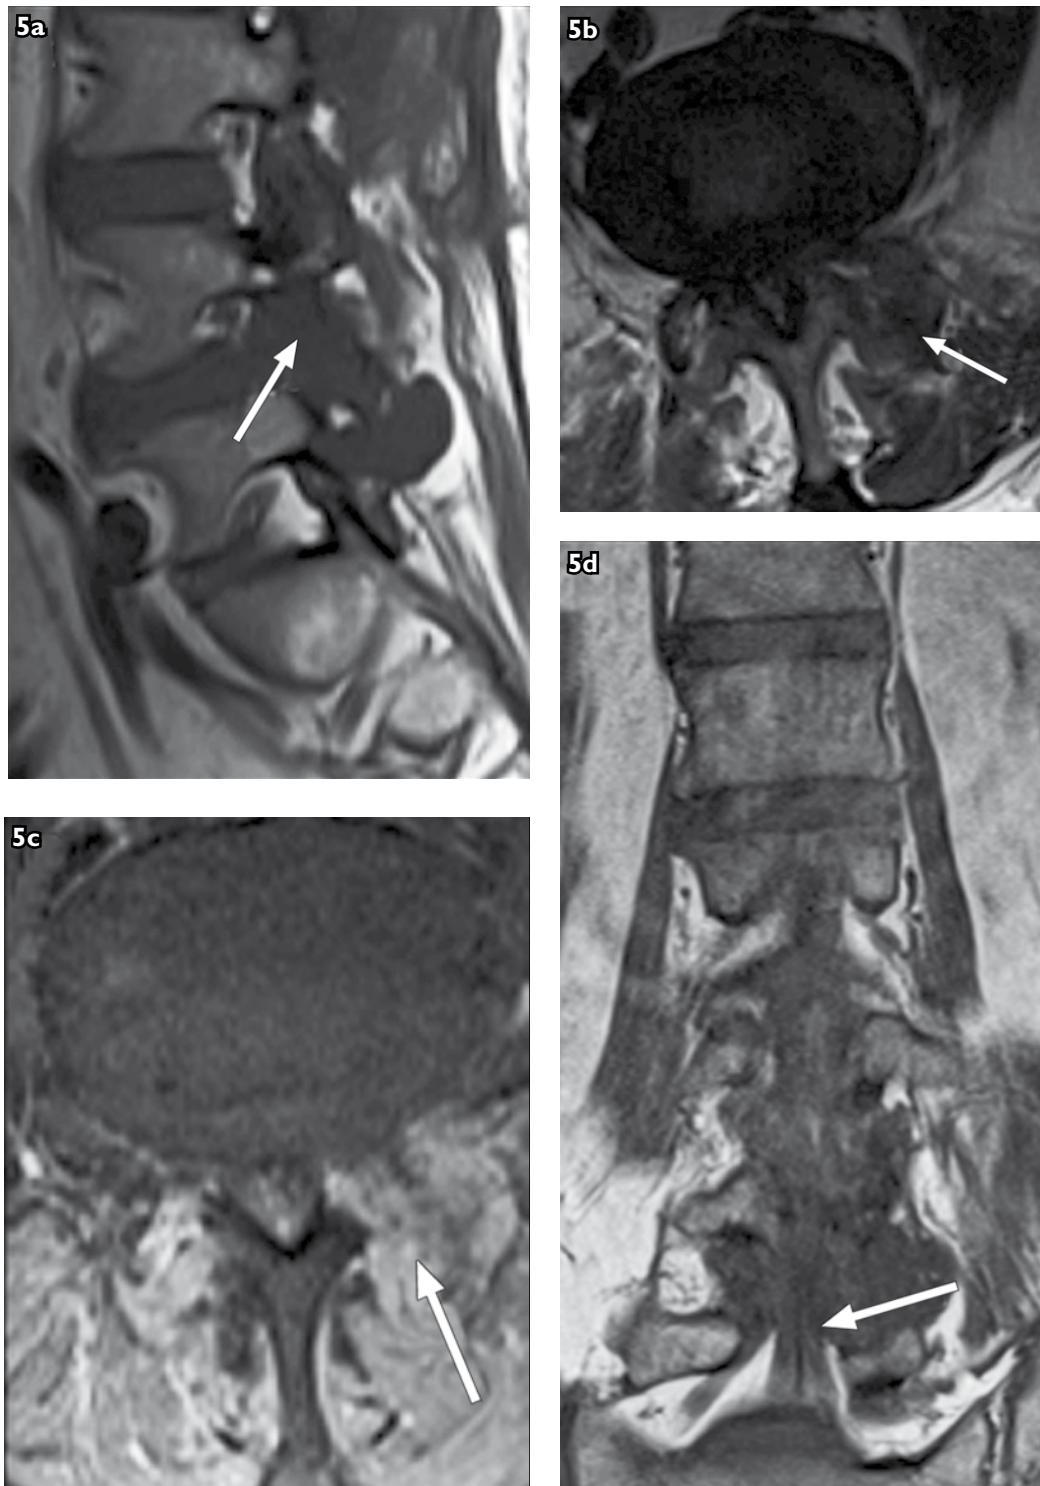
(a) Sagittal T1-WI MR image of the lumbar spine shows the L4/5 facet joint replaced by a well-defined lobulated T1-WI hypointense tophus (arrow). (b) Axial T2-WI MR image of L4/5 shows that the tophus is of intermediate signal intensity (arrow). (c) Post-contrast, fat-saturated axial T1-WI MR image of L4/5 shows that homogenous enhancement of the tophus is most common (arrow). (d) Coronal T1-WI MR image of the lumbar spine shows the tophus causing indentation of the thecal sac and spinal canal stenosis (arrow).
